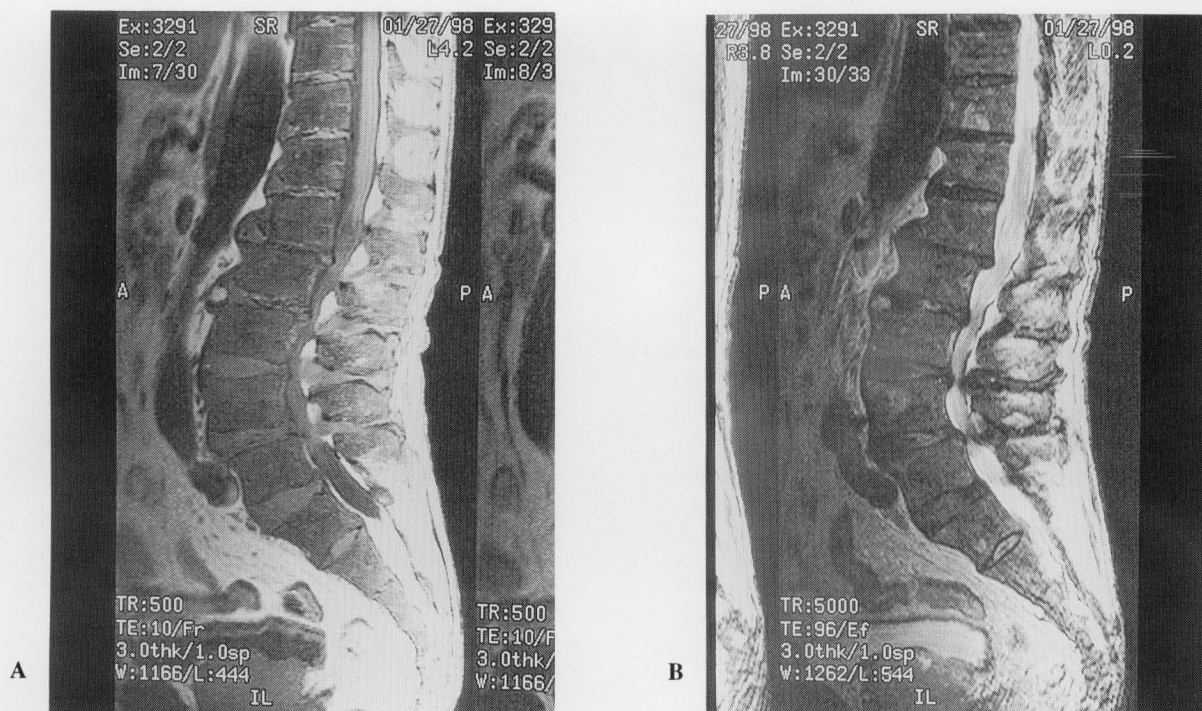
T1 (A) and T2 weighted (B) magnetic resonance images of the lumbar spine. Signal intensity of the vertebrae is decreased on both images, indicating fatty marrow replacement.
